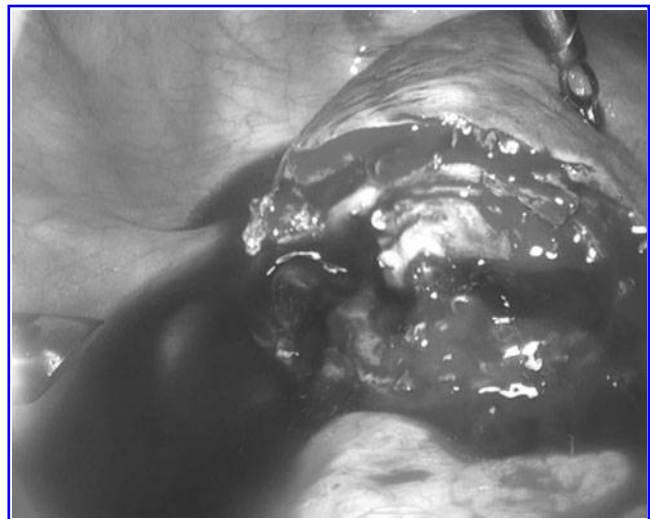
Laparoscopic picture depicting the myoma bed. Notice that the endometrial cavity was entered in a small area (about 1 cm) and a moderate amount of bleeding from the myometrium was observed. Taken from ISBN: HB 9781107029743. Edited by Botros R.M.B. Rizk and Elizabeth Puscheck. Ultrasonography in Gynecology. Figure 17 in the book chapter "Transvaginal ultrasound scan findings of uterine fibroid effect on treatment plan." By Dr. Mostafa Abuzeid and Salem Joseph. Copyright © 2012 Cambridge University Press. Reprinted with the permission of Cambridge University Press.
